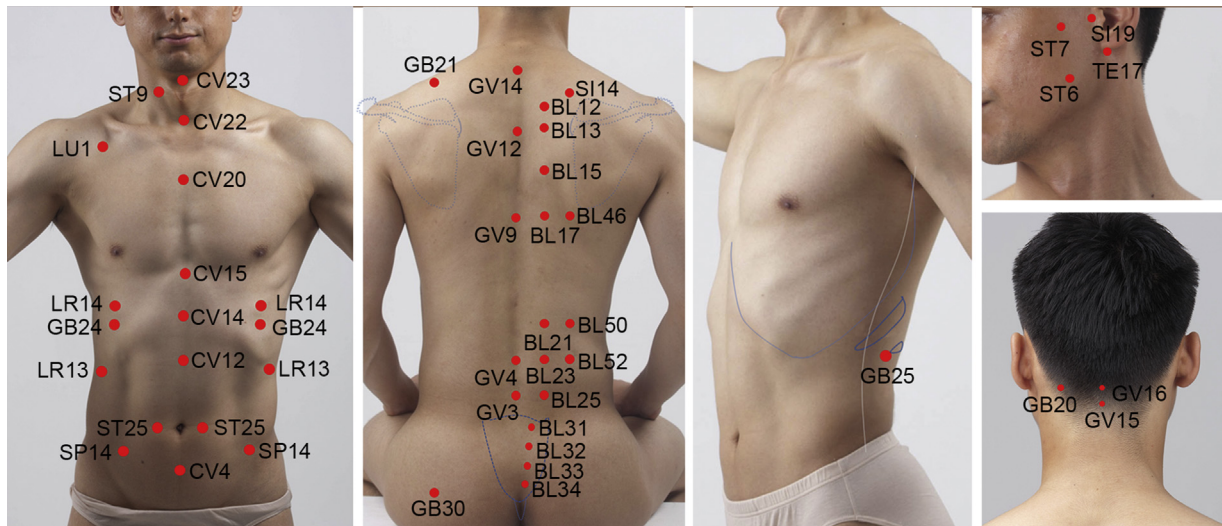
Acupuncture points selected for ultrasound imaging.
